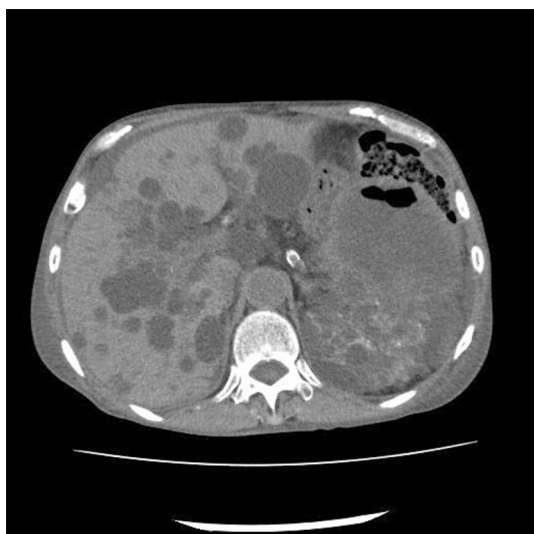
Abdominal CT scans. Gas shadow was observed in the infection renal cyst
